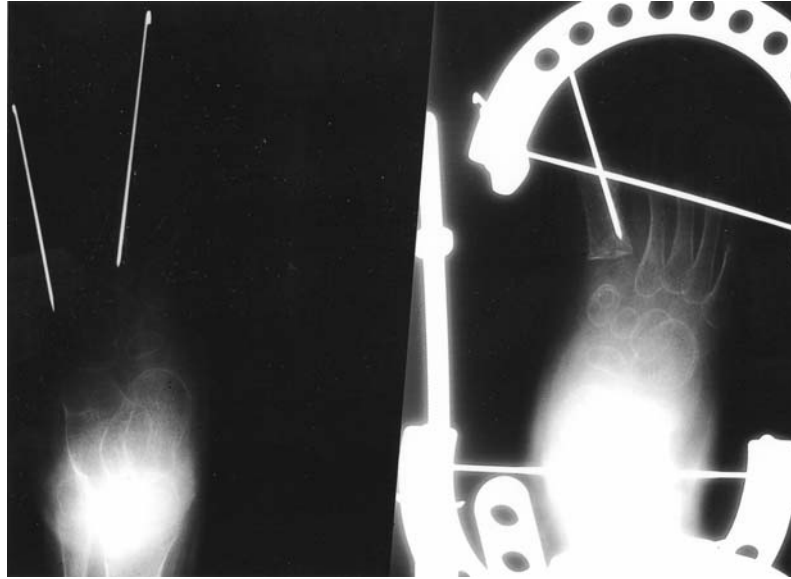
(Right) Dorsal radiograph of a foot with a hallux valgus deformity corrected with soft-tissue release and pinning. (Left) Dorsal radiograph of dislocation of the number two and five metatarsals that was treated with soft-tissue release, pinning, and skin grafting.
